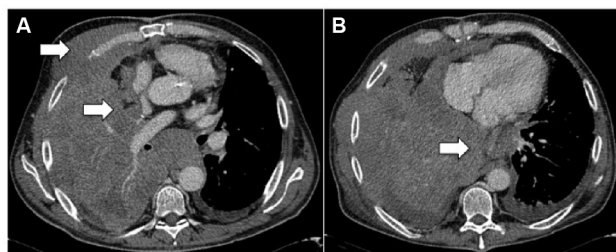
Contrast-enhanced computed tomography showing extensive invasion of the mediastinum, pericardium, and chest wall (arrows).
